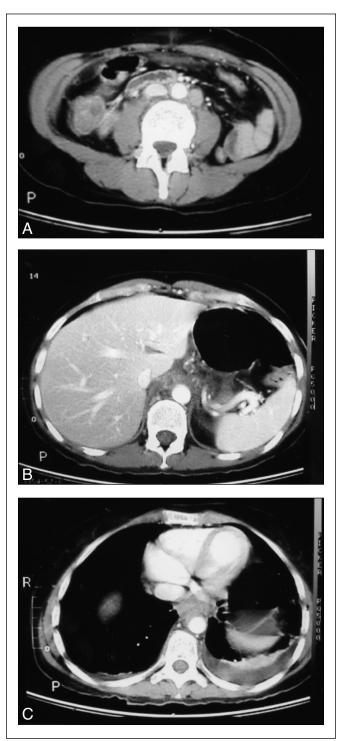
The patient's CT of the abdomen obtained postoperatively revealing (A) periaortic adenopathy, (B) infiltration of the aorta by the tumor, and (C) periaortic mass with invasion of the aorta and pericardium by the tumor.
